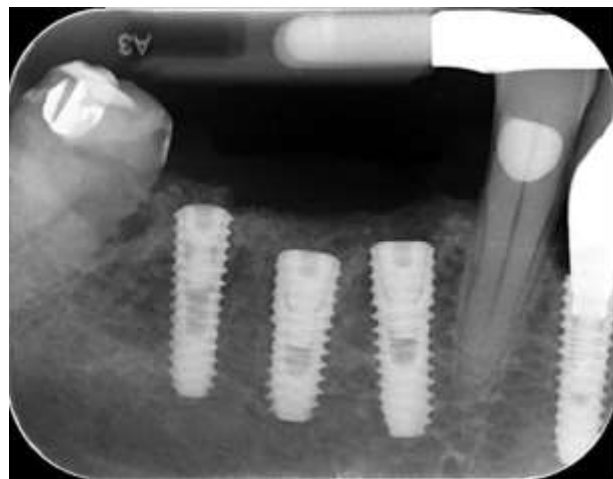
Periapical x-ray after 6 months
